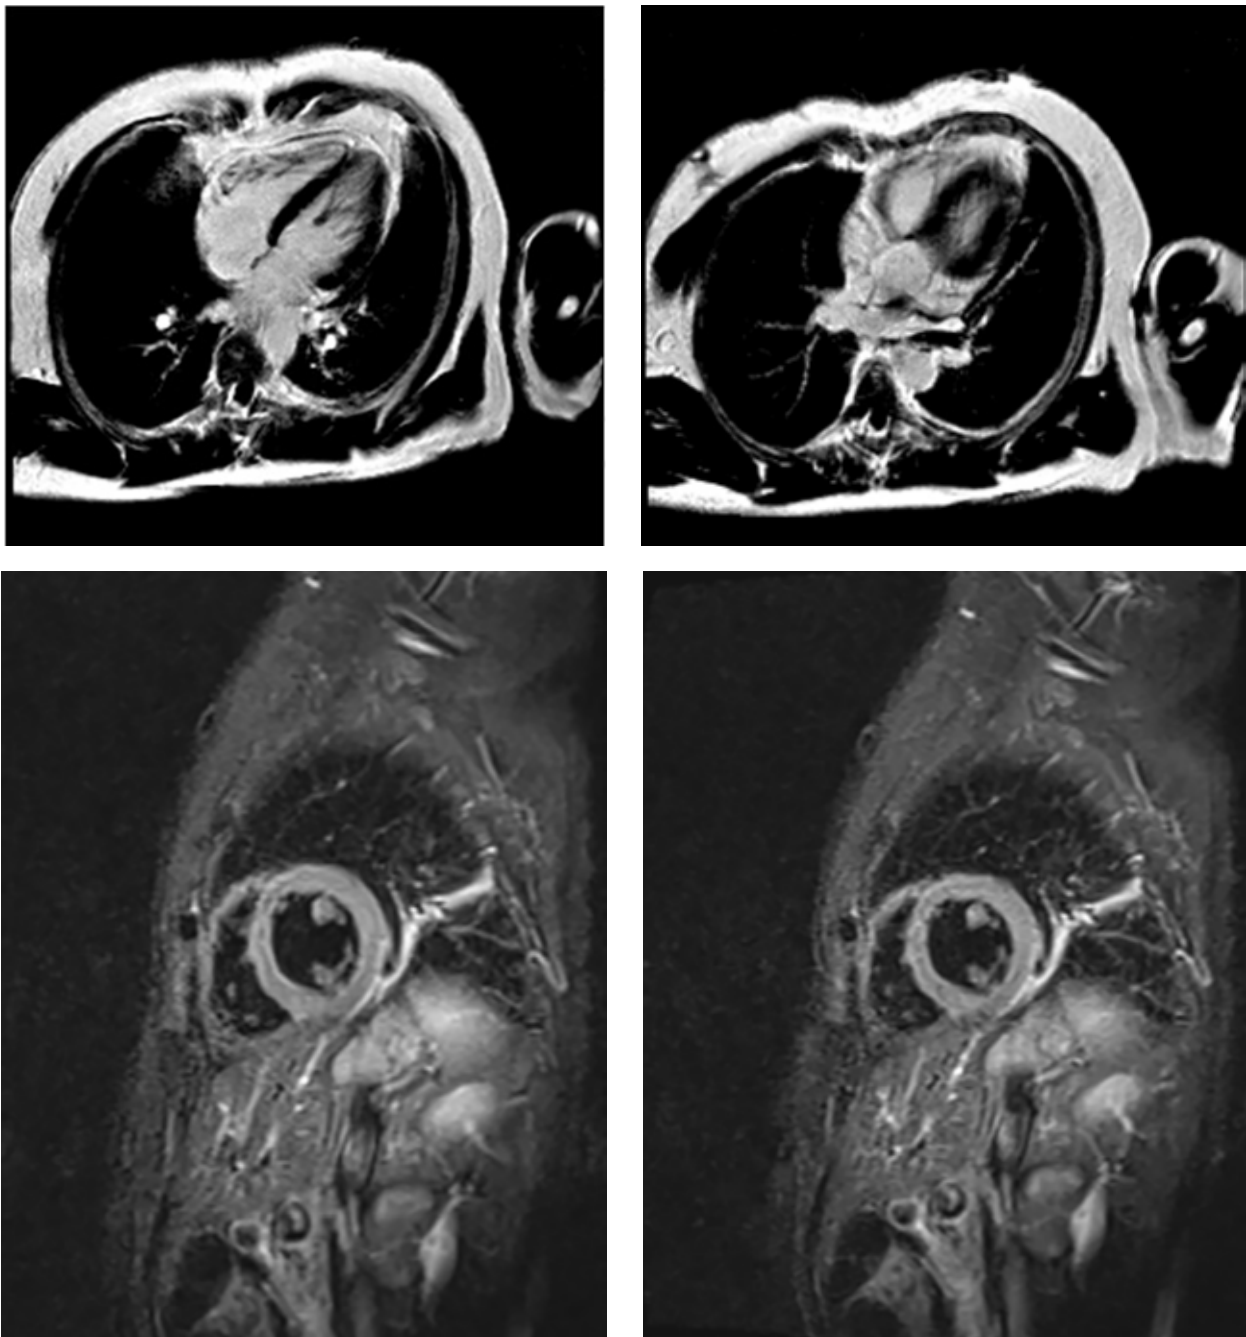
MRI showing patchy distribution and late enhancement myocardial areas of the anterolateral wall of left ventricle, suggesting myocarditis
